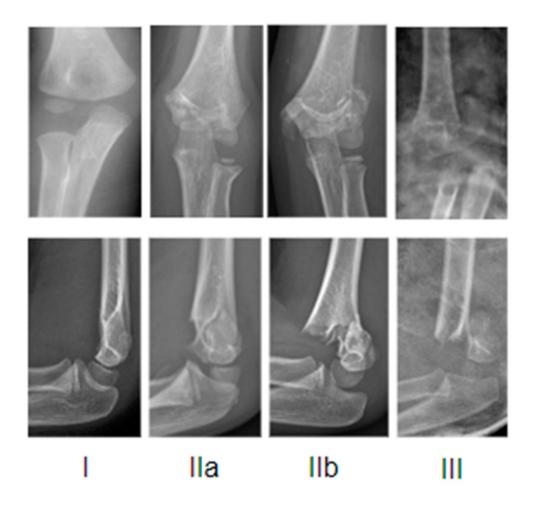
Radiographs representing the Gartland classification [46].
